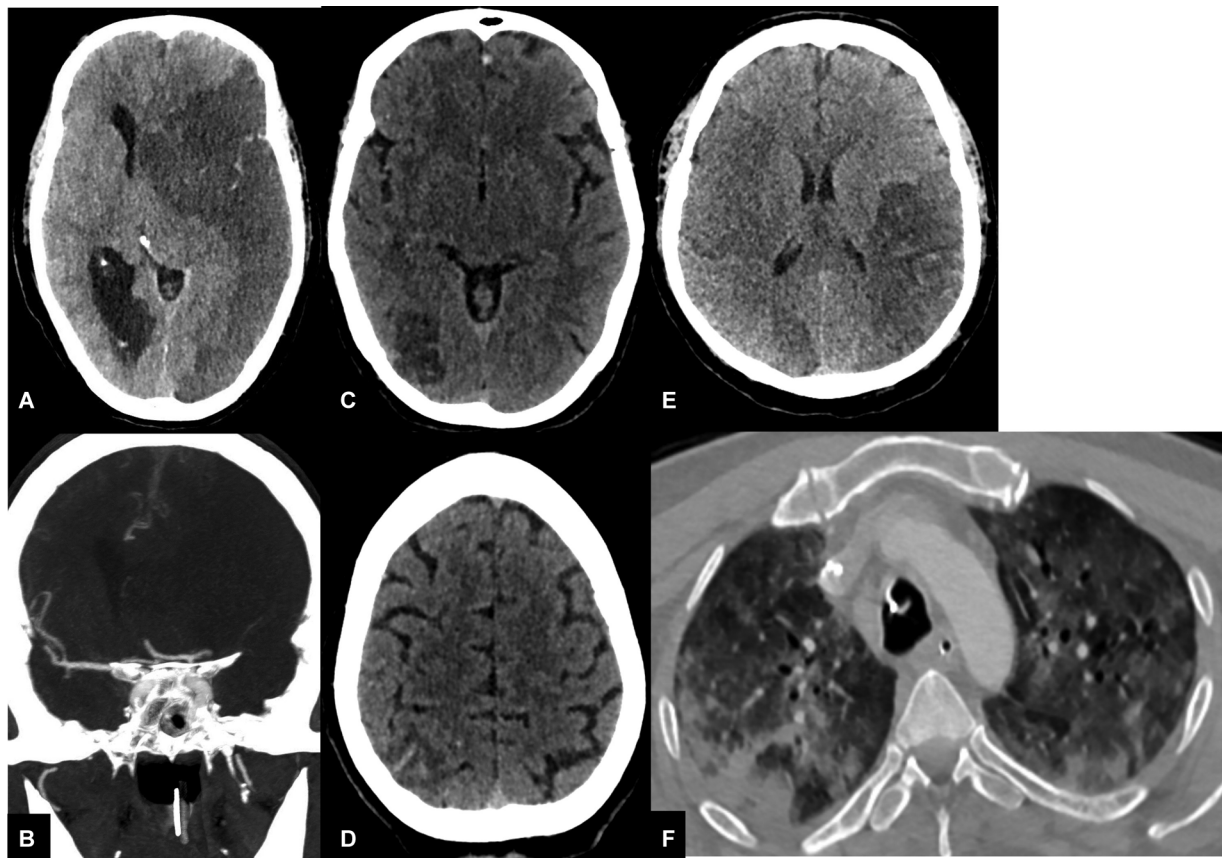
Acute ischemic stroke in coronavirus disease 2019 (COVID-19) patients. A 71-year-old COVID-19-positive patient presenting with right-sided hemiplegia of 48 hours duration. The axial noncontrast computed tomographic (CT) images (A) show complete left middle cerebral artery (MCA) territory infarct with significant mass effect and midline shift, with occlusion of the proximal M1 segment of left MCA on coronal CT angiogram maximum intensity projection image (B). Another patient with left hemiparesis shows embolic infarcts at right occipital and superior parietal lobule (C and D). Sudden decrease in Glasgow coma scale score in an intubated patient shows bilateral middle cerebral artery infarcts (E). Note the peripherally oriented opacities in bilateral upper lung fields (F).
